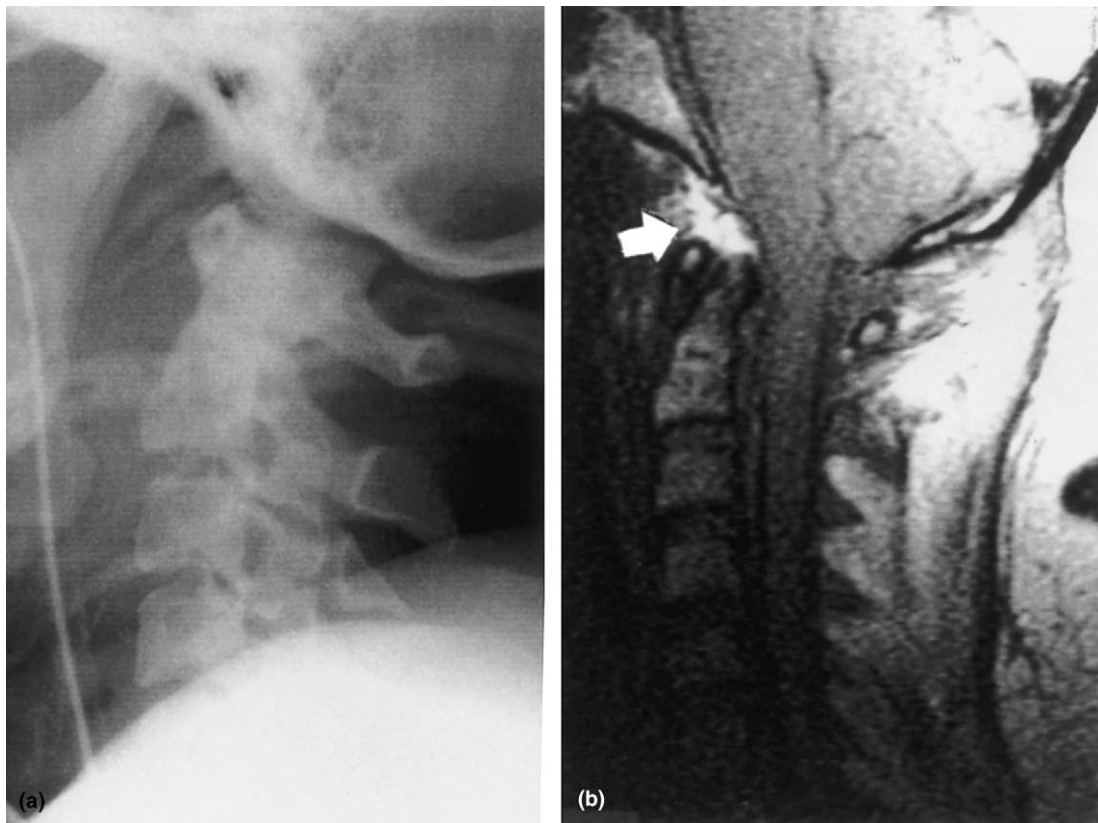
(a) Lateral cervical radiography showing the occipital–atlantal subluxation; and (b) MR image showing the ligamentous injury of the anterior ligaments at the O–C junction (arrow).
